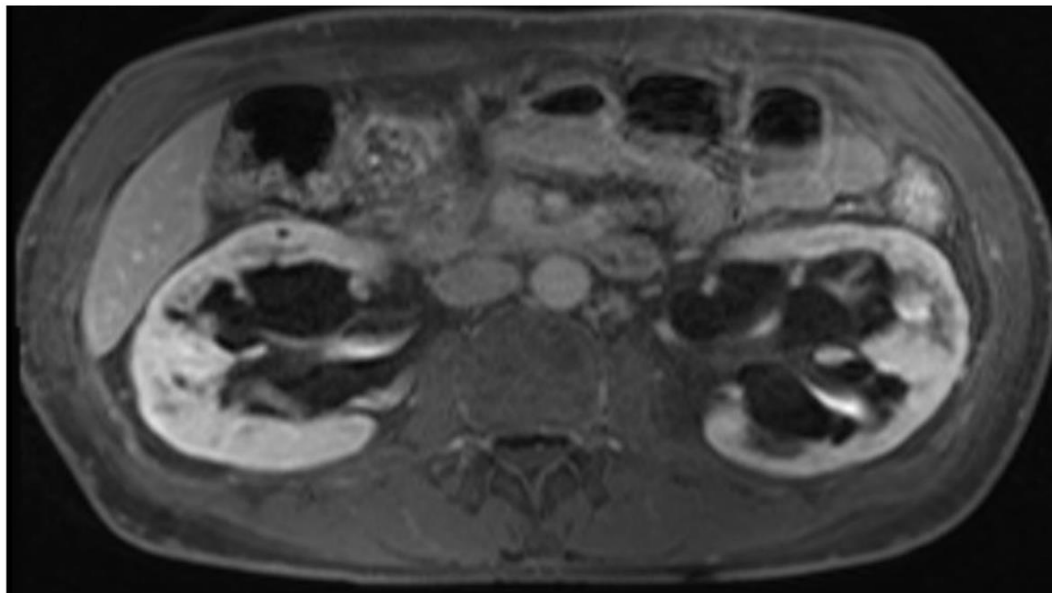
Parapelvic cysts in Fabry disease. MRI scan demonstrating bilateral parapelvic cysts (McCloskey, Brennan and Sayer 2018).
